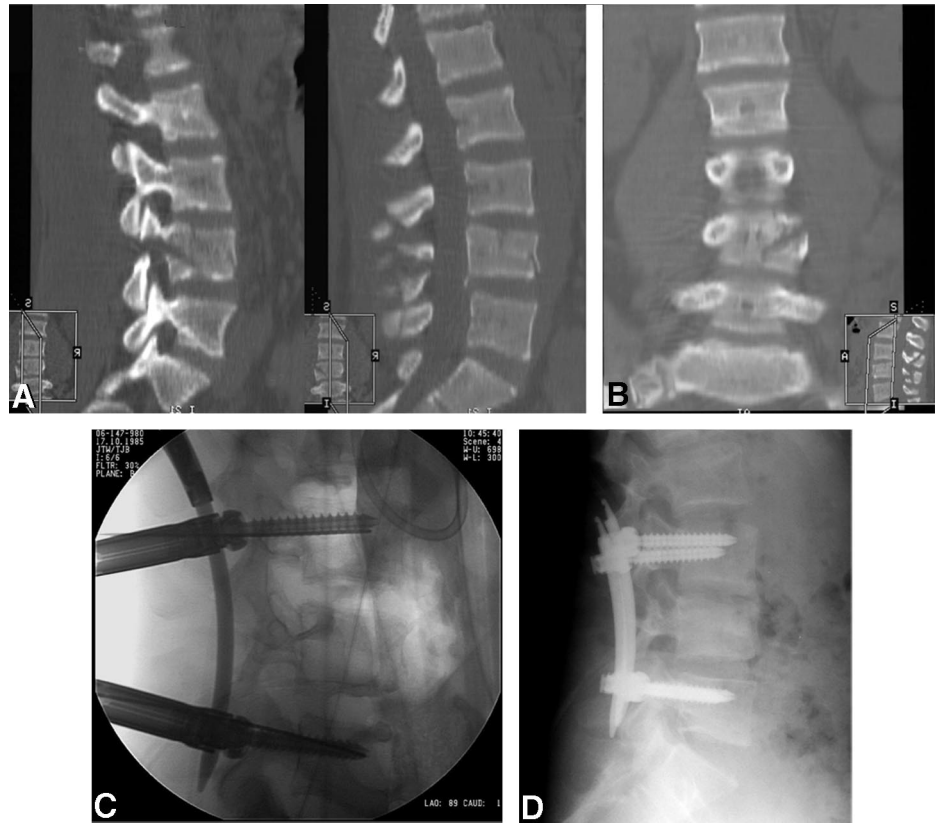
A, Preoperative sagittal computed tomography (CT) reconstruction demonstrating a predominantly bony flexion-distraction injury at L4. B, Preoperative coronal CT reconstruction demonstrating the fracture extending up through the pedicle. C, Intraoperative image demonstrating percutaneous placement of intervening 5.5-mm rod. D, Upright postoperative lateral radiograph demonstrating reduction and stabilization of the distractive flexion injury.
